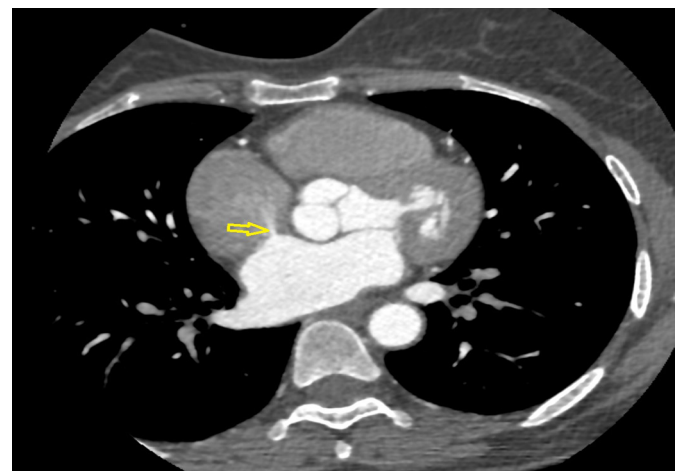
Case 2. Axial CT image. Yellow arrow: small secundum-type ASD
